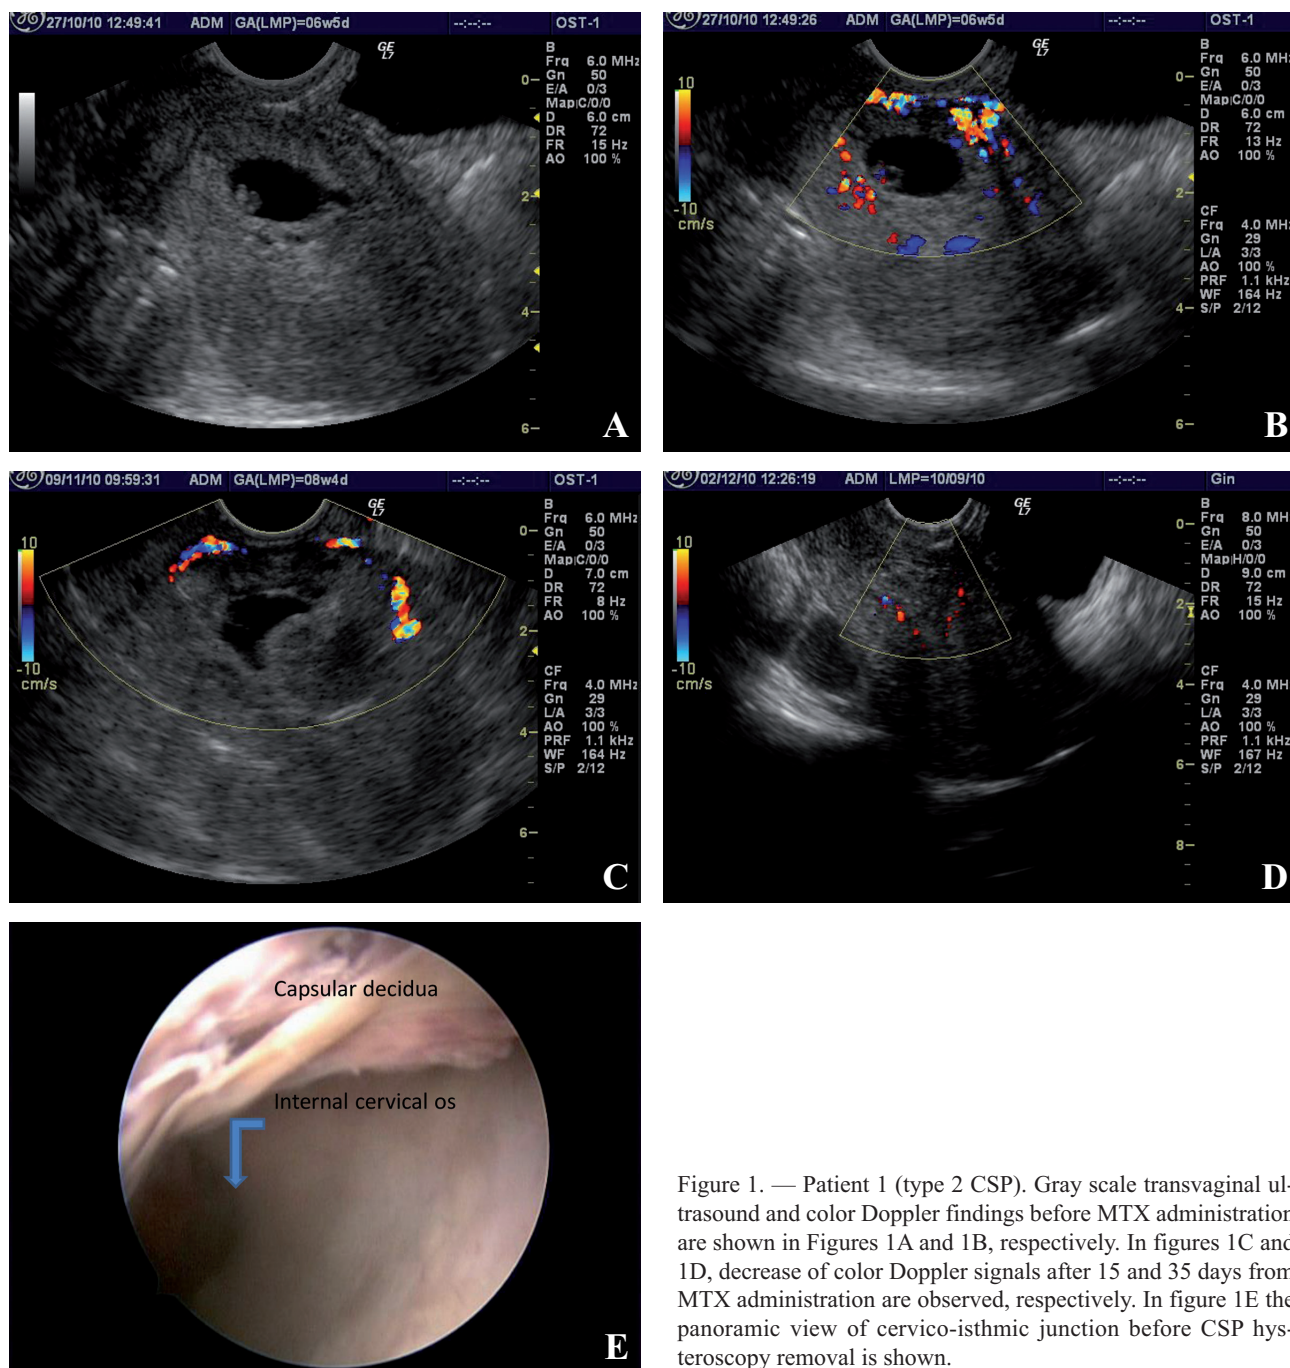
Patient 1 (type 2 CSP). Gray scale transvaginal ultrasound and color Doppler findings before MTX administration are shown in Figures 1A and 1B, respectively. In figures 1C and 1D, decrease of color Doppler signals after 15 and 35 days from MTX administration are observed, respectively. In figure 1E the panoramic view of cervico-isthmic junction before CSP hysteroscopy removal is shown.
